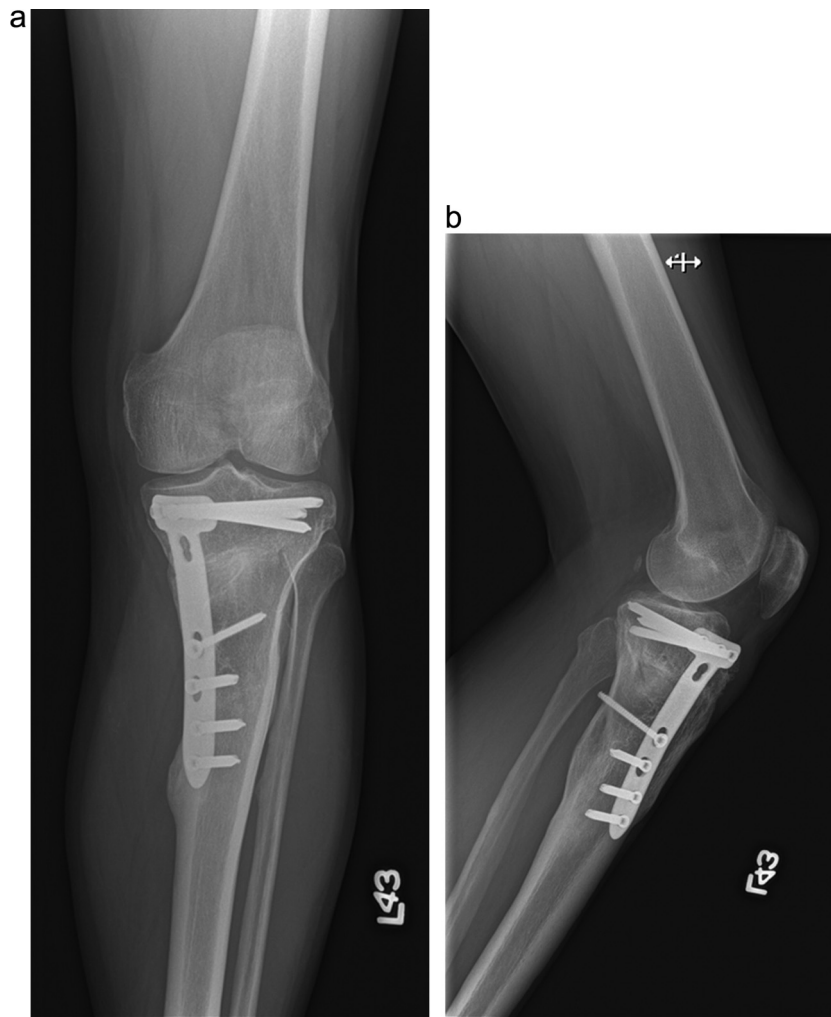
(A and B) AP and lateral radiograph at 6 months post-op demonstrating healed fracture.
